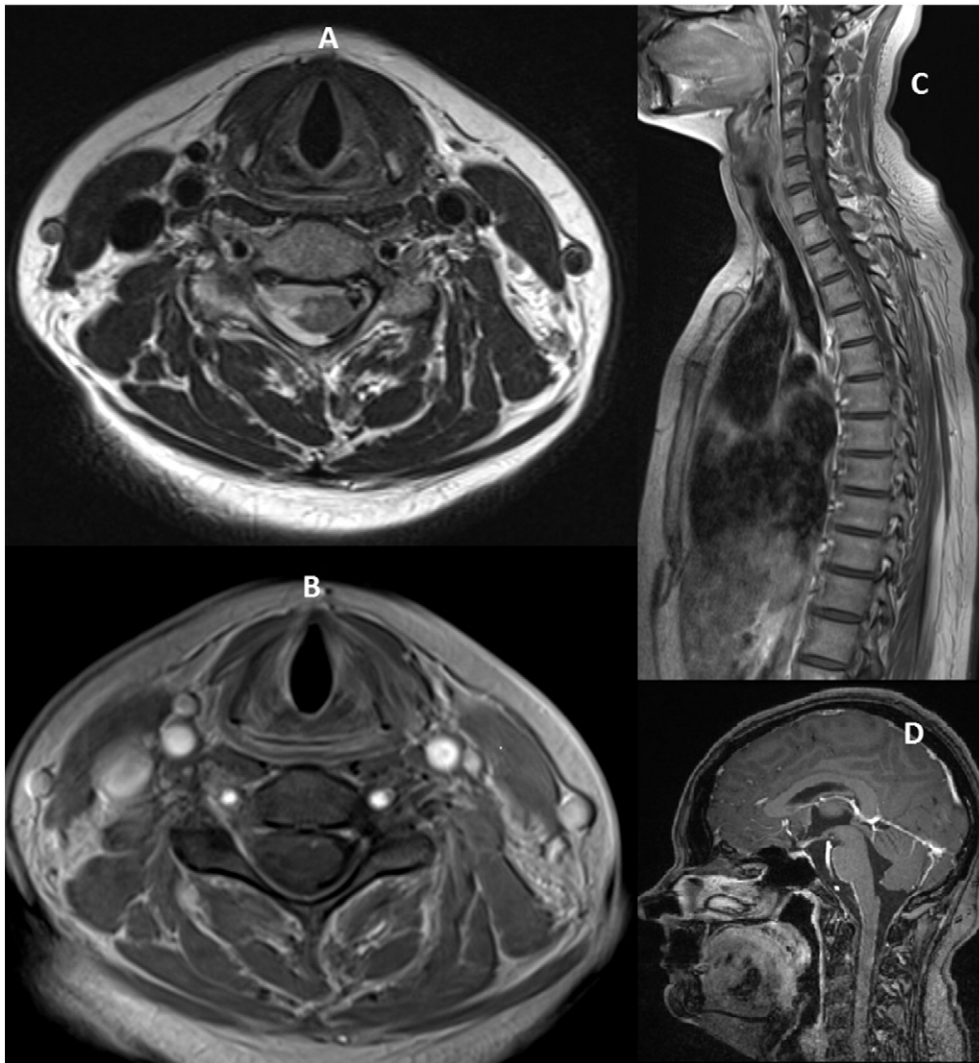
A: MRI axial T2-weighted image at level C4 showing an intraparenchymal lesion with meningeal affection, B: T2 post-contrast axial T2-weighted image at level C4 showing a week enhancement with intradural intraparenchymal lesion and leptomenigeal enhancement. C: MRT sagittal T1-weighted image of the lumbar and thoracic region showed showing an intraparenchymal location at level C4 level, D: MRT of brain showing the leptomenigeal enhancement up to Brainstem.
